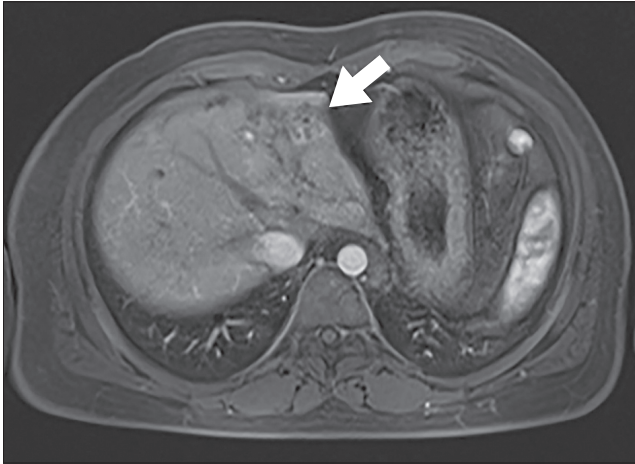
Preoperative MRI of case 1. Multiple intrahepatic bile cysts were in the left lobe of the liver (arrow).
